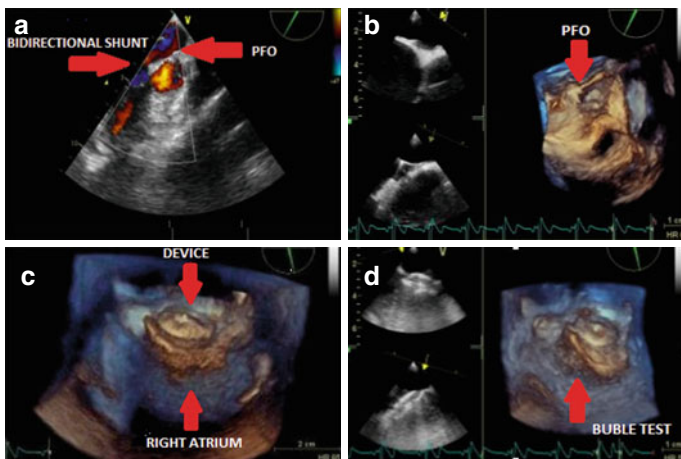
PFO closure in a patient with PA-IVS submitted to RV decompression. (a) Bidirectional shunt at level of a tiny PFO as imaged at color Doppler analysis. (b) 3D transesophageal echocardiography showing the patent foramen ovale probed by a guide wire during the occluding test and (c) after the device implantation. (d) The bubble test after the final device deployment fails to show any right-to-left shunt
